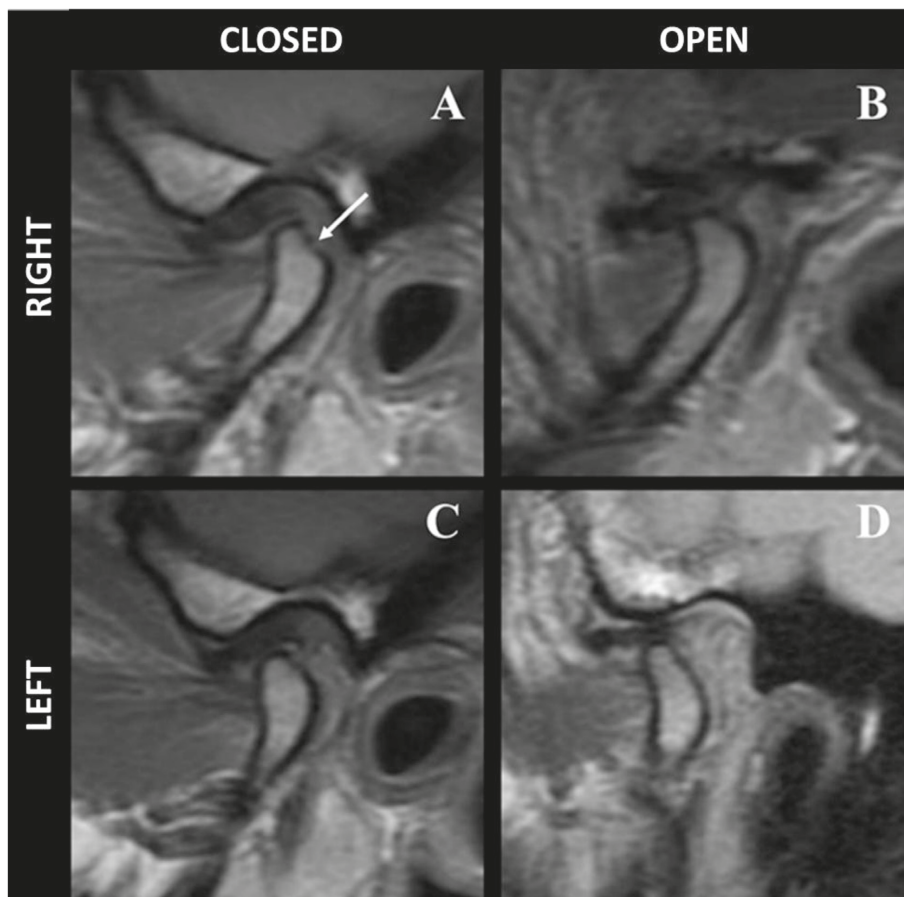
Magnetic resonance imaging of the temporomandibular joints. (A) Right TMJ in the closed-mouth position showing anterior displacement of the articular disc, associated with cortical irregularity and erosive changes of the mandibular condyle (white arrow). (B) Right TMJ in the open-mouth position demonstrating absence of disc recapture, with the articular disc remaining anterior to the mandibular condyle, consistent with anterior disc displacement without reduction. (C) Left TMJ in the closed-mouth position showing a normally positioned articular disc, with the posterior band interposed between the mandibular condyle and the articular surface of the temporal bone. (D) Left TMJ in the open-mouth position demonstrating maintenance of a physiological disc–condyle relationship, with appropriate disc translation during condylar movement.
